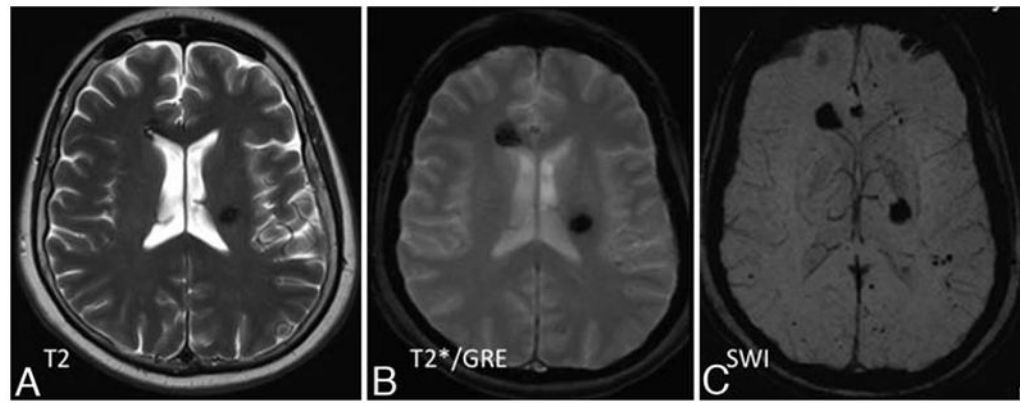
Representative T1-weighted (A), T2*GRE (B), and SW (C) MR images obtained in a patient with a family history of familial CCM disease, who presented for routine MR imaging screening. The T2 sequences (A) reveal 2 suspected CCM lesions, which were better delineated on T2*GRE sequences. The T2*GRE sequences (B) also suggesting perhaps 1 or 2 additional subtle lesions. The SW images (C) reveal many additional lesions throughout the brain.
